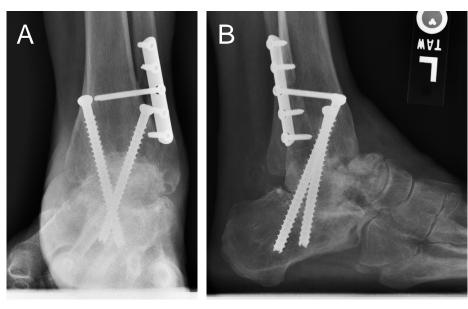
Weight bearing radiographs (A, B) 8 months after TTC fusion with femoral head allograft, with varus deformity.
